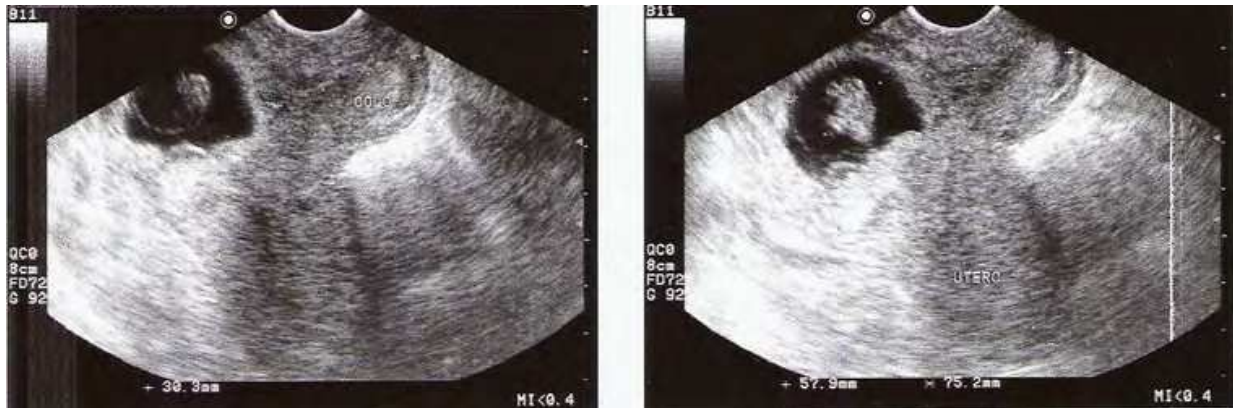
Longitudinally oriented transvaginal ultrasound of the uterus demonstrating an empty uterus, an empty cervical canal, the gestational sac being located in the anterior part of the isthmus portion of the uterus with a diminished myometrial layer and a discontinuity in the anterior wall of the uterus (Elito, Camano, 2010a).
